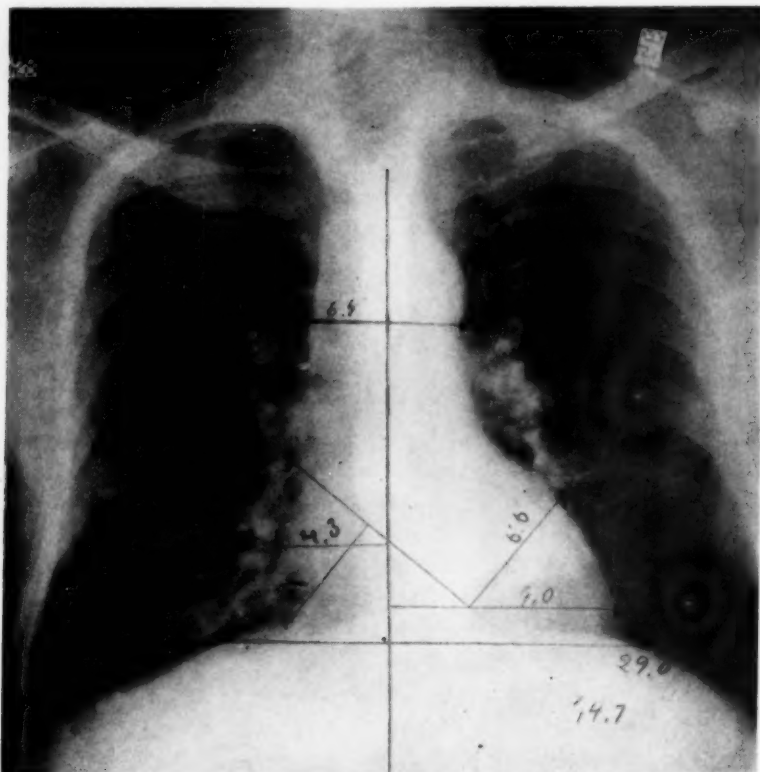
Roentgenograph made one month after figure 1, the signs of infection having subsided.
